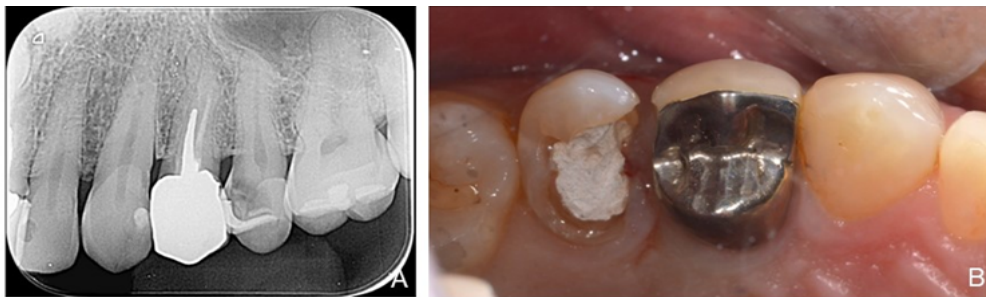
A) Initial X-ray; B) Initial assessment after removal of caries and pre-existing restoration. Observe the presence of the mesial subgingival margin.
